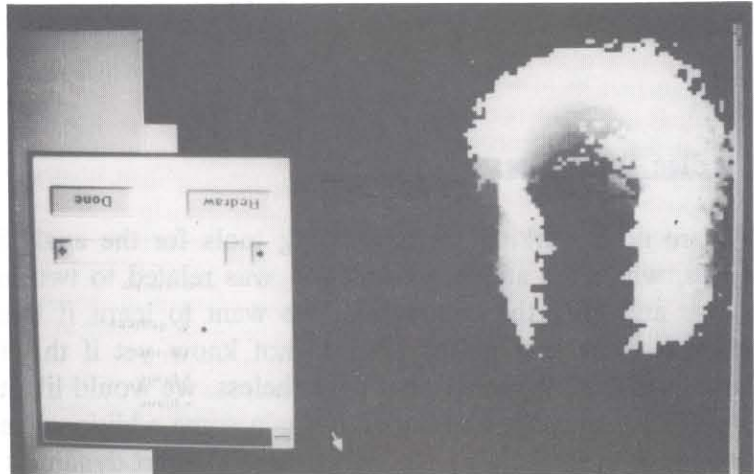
3D reconstruction of a stenosed artery as seen by an ultrasound probe inside the vessel.
